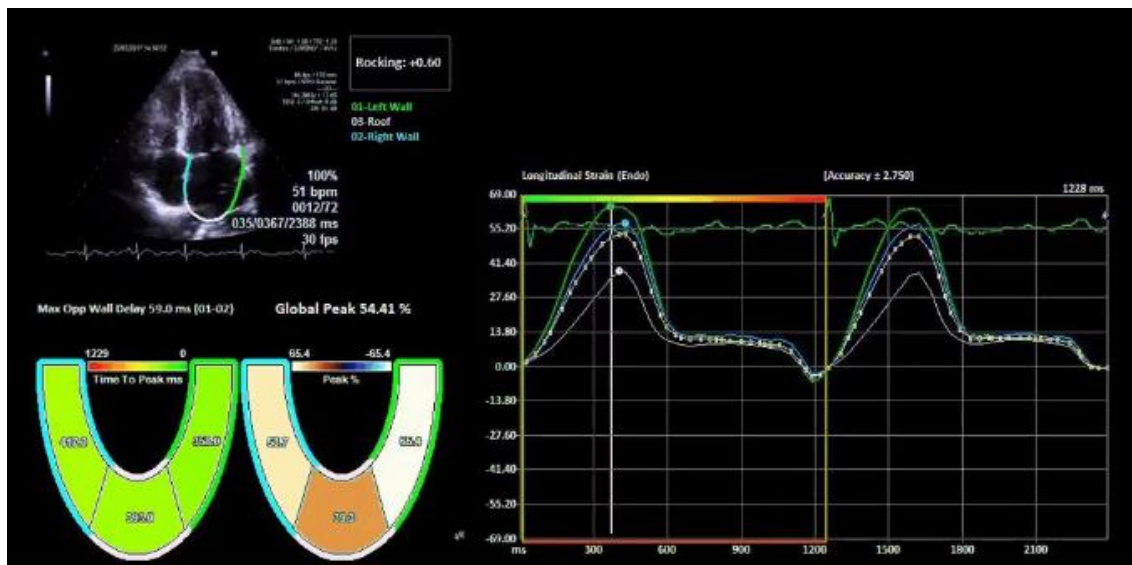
Apical chamber view, longitudinal strain curve of the Left Auricle by speckle tracking echocardiography.
